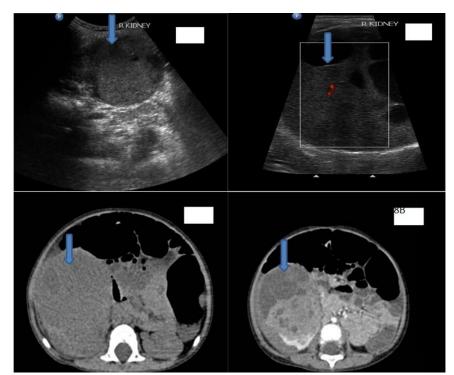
Wilms Tumor: well-defined solid cystic lesion involving lower pole of right kidney. Color Doppler showing vascularity within the lesion. NECT and CECTshowing heterogeneously enhancing lesion in lower pole of right kidney with areas of necrosis.
